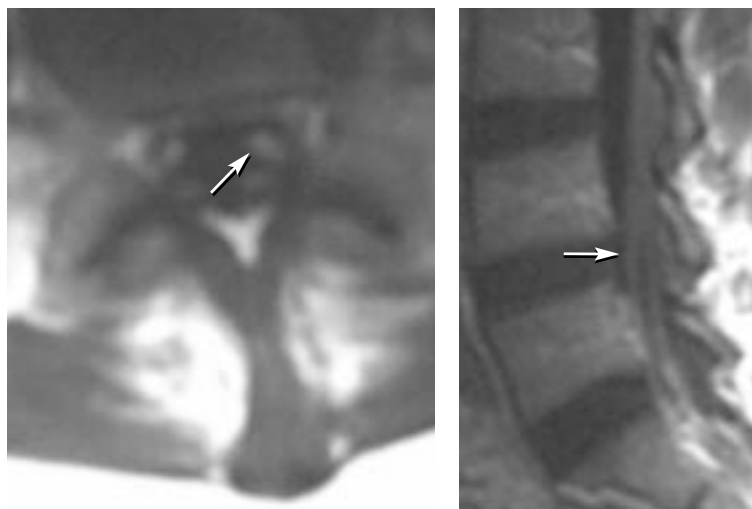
Axial (left) and sagittal (right) MRI images of the lumbar spine. The nerve roots in the cauda equina are clearly seen (arrows), consistent with perineural inflammation.
